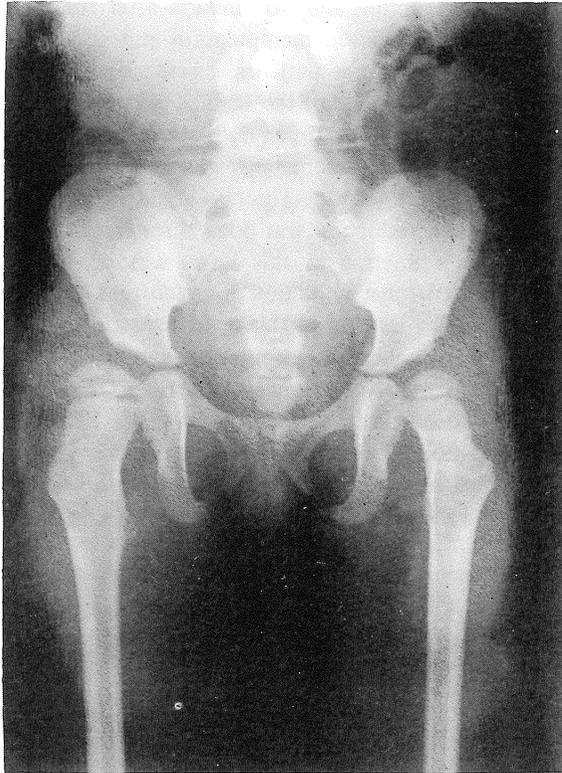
Radiograph two years after bilateral open reduction through the Ludloff approach, both hips are subluxed resulting in Severin grade IV hips.
